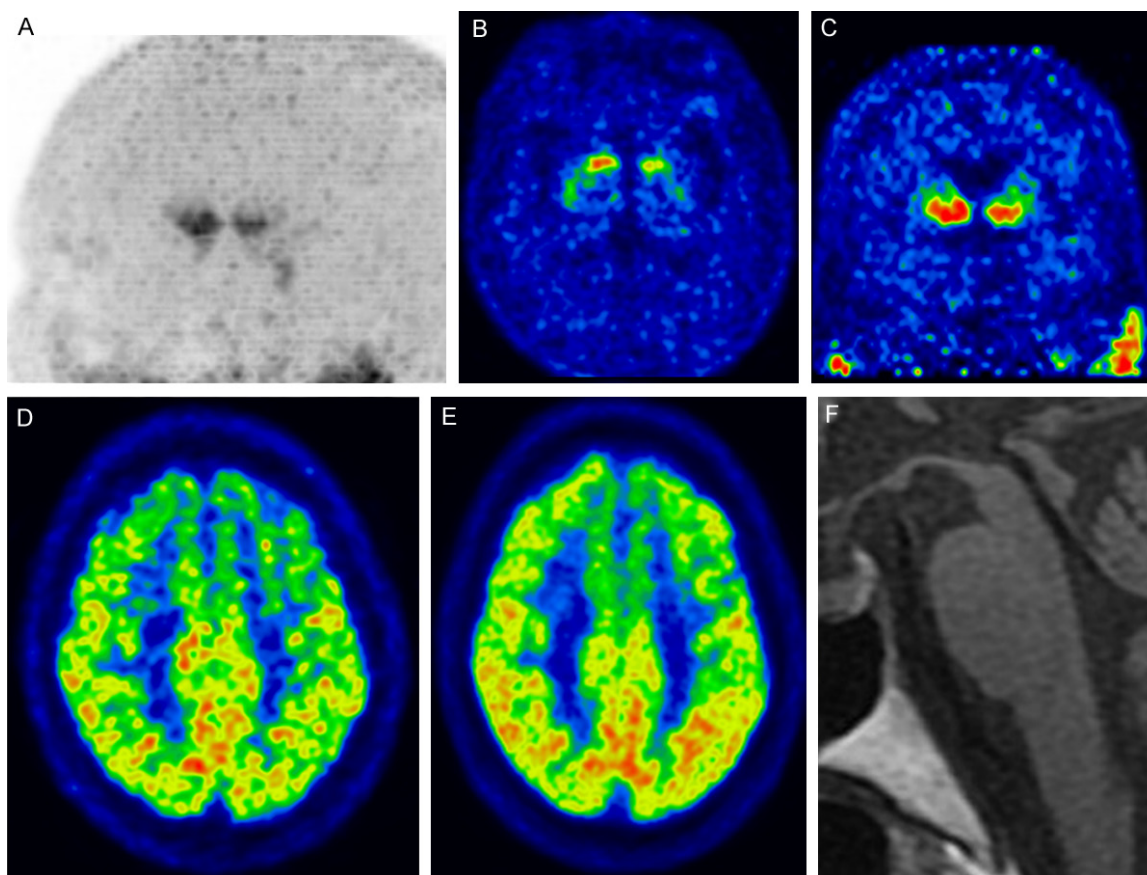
Progressive supranuclear palsy-Richardson syndrome (PSP-RS) (A) Maximum intensity projection image of DAT imaging using ^{18}F -FP-CIT showing prominently decreased tracer uptake in the caudate nucleus and decreased tracer uptake in the putamen. (B) Transaxial and (C) coronal DAT images showing decreased tracer uptake in both the anterior caudate nucleus (left dominant). (D) Early perfusion image of ^{18}F -FP-CIT and (E) glucose metabolism of ^{18}F -FDG showing decreased perfusion and glucose hypometabolism in the cerebellum. (F) Sagittal T1 MRI showing atrophic changes in the midbrain with preserved pons, known as the “hummingbird sign” or “penguin sign”.
